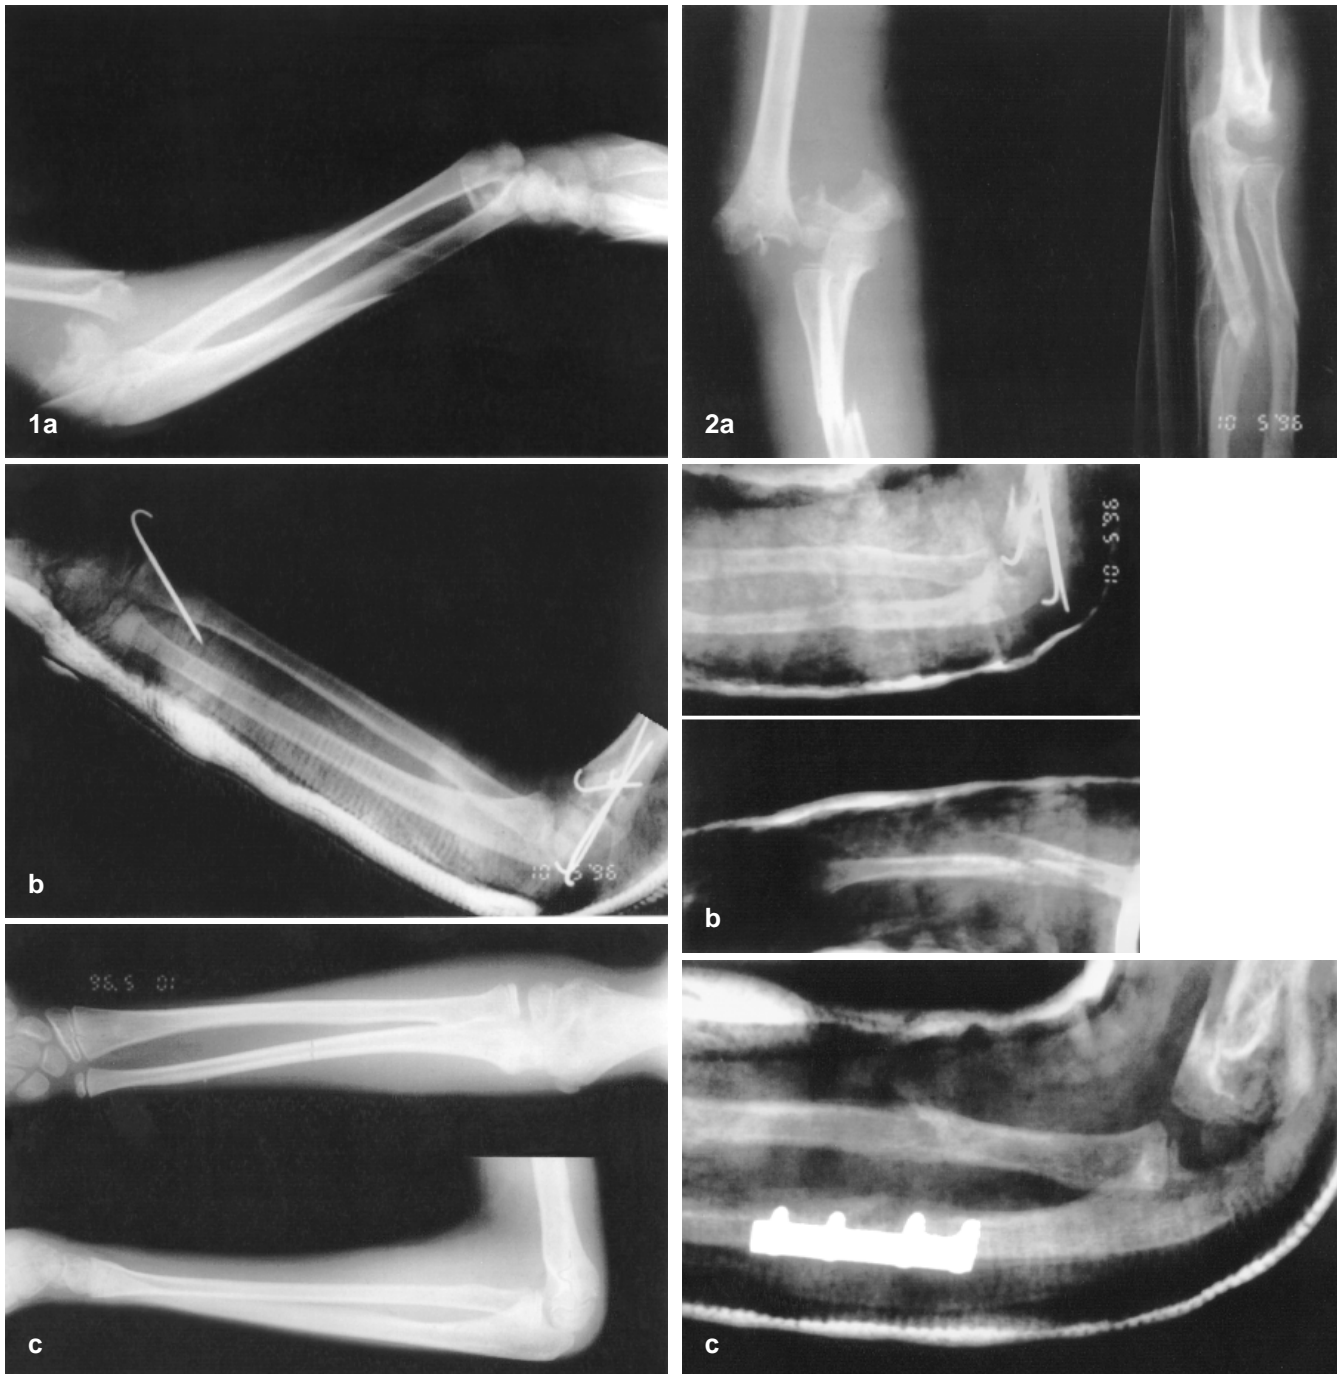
Radiographs of the right arm of a 10-year-old boy after a fall from a tree. He sustained an open elbow injury and a closed distal forearm injury. a Long lateral film showing marked displacement of both fractures. b After reduction and K-wire fixation. c One year post-injury
